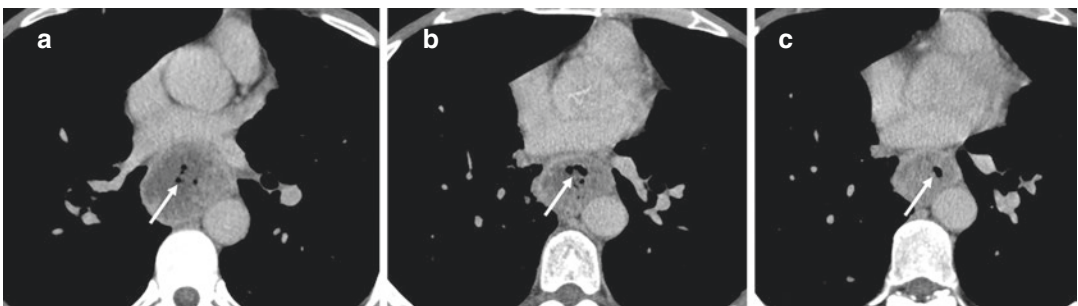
Nodal-esophageal fistula in a patient with active tuberculosis who presented with dysphagia. (a–c) Axial contrast-enhanced CT images show necrotic enlarged
